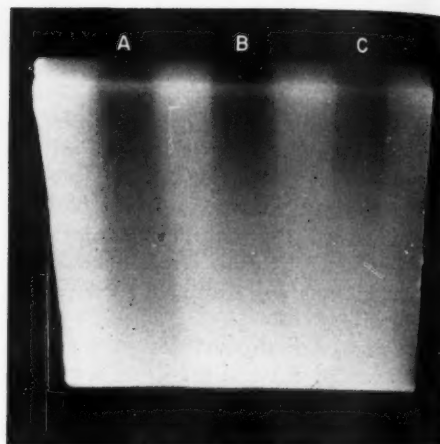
Increase in depth dose with higher quality x-rays, 2,000 r at surface of each field. A. 2,000 kvp, 13 mm. Cu h.v.l. B. 280 kvp, 1.3 mm. Cu h.v.l. C. 200 kvp, 0.65 mm. Cu h.v.l.
